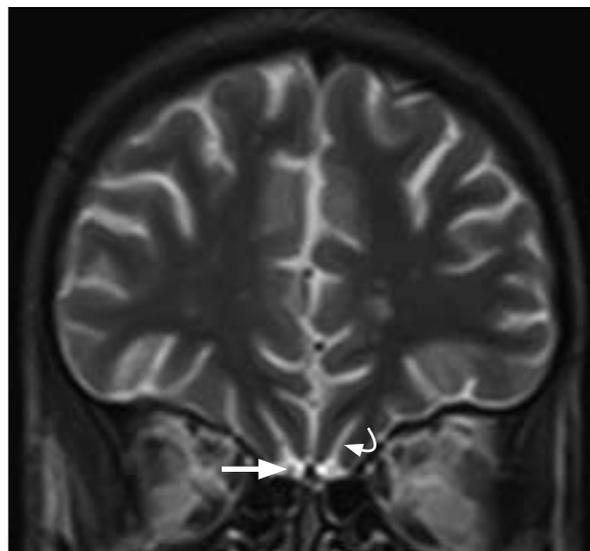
T2-weighted magnetic resonance imaging of the brain of a normal individual
